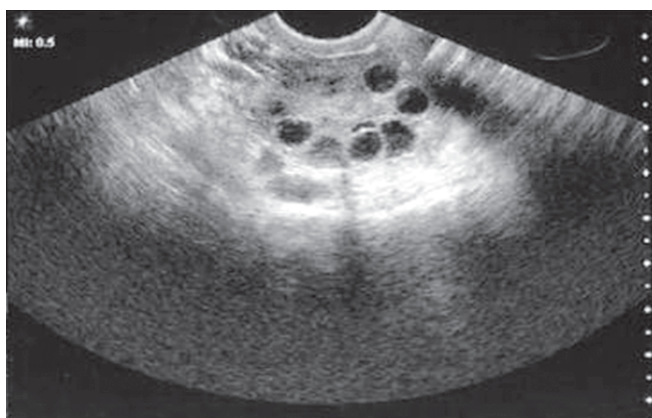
Typical Ultrasonographic appearance of an ovary in PCOS.
